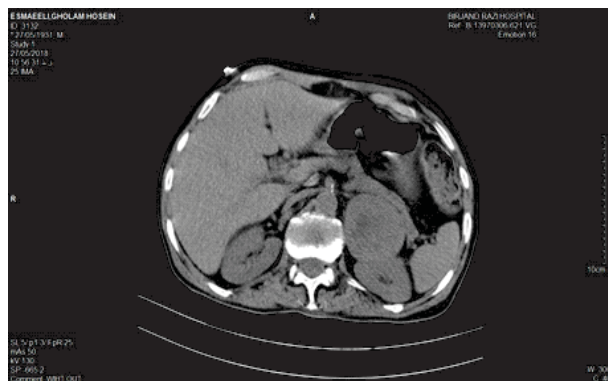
CT Scan of Left Adrenal Mass
